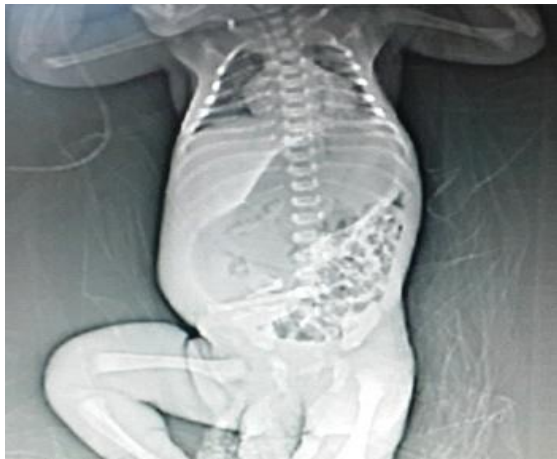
CT scan showing an intraperitoneal cyst
